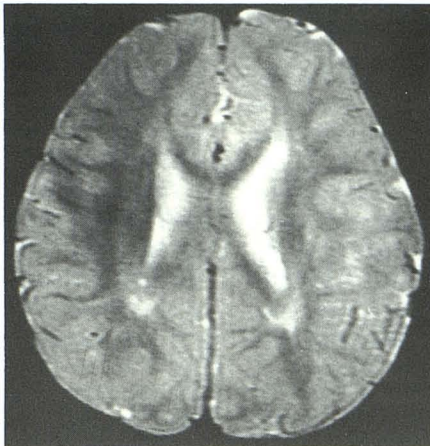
Minimal periventricular high signal is noted on long spin-echo MR image 2500/50 in patient with carnitine deficiency.
